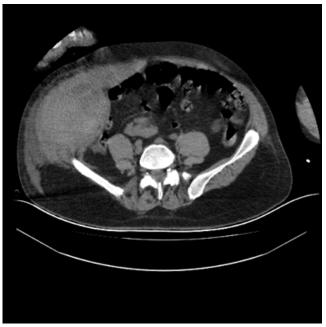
Abdominal and pelvic CT scan (A right flank hematoma reaching approximately 10 cm in width)
